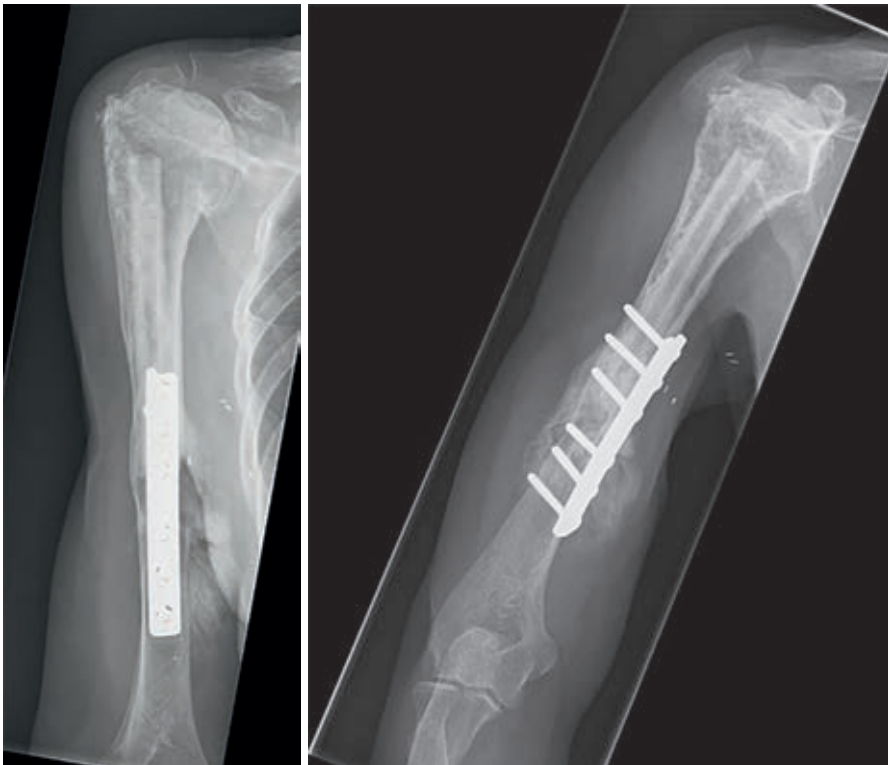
Conventional anteroposterior and lateral radiographs, taken 15 years after resection of the proximal humerus for a low-grade osteosarcoma in a 46-year-old female patient. The allograft was fixed to host bone using a plate. A fibular strut graft can be identified in the intramedullary canal. Later, a transhumeral amputation was performed for a soft-tissue recurrence.
